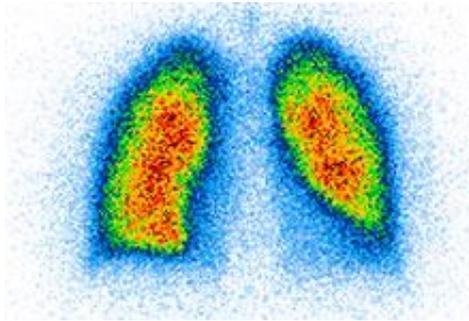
Lung scintigraphy
